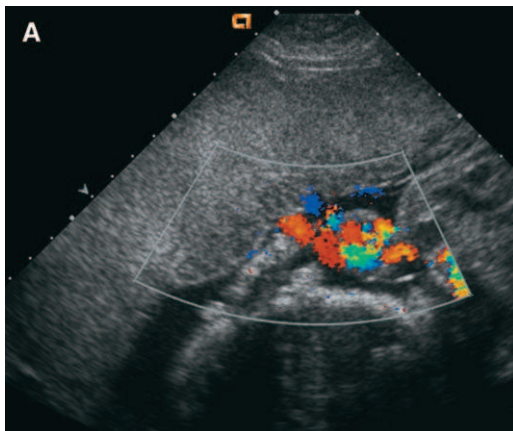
Color Doppler sonograms show cord insertion sites into the shared anterior monochorionic placenta. (A) Central cord insertion site for this twin. (B) Eccentric, almost marginal cord insertion site at the lateral aspect of the placenta for this twin.
